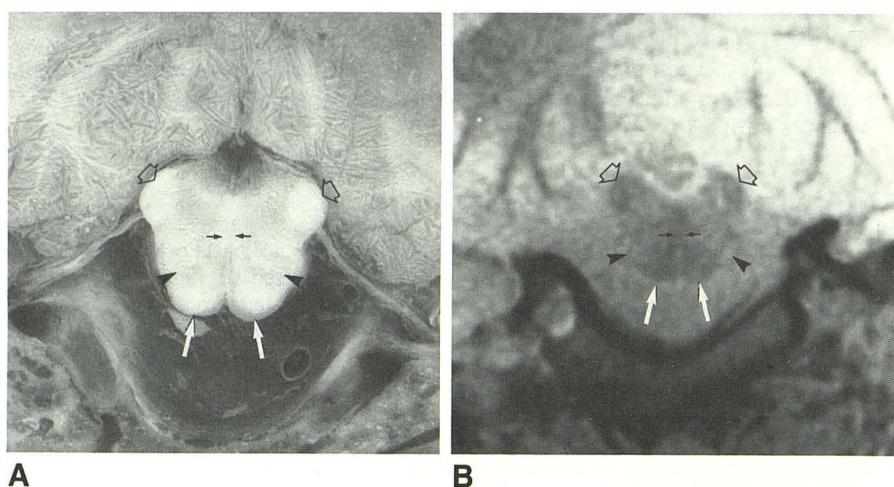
Anatomic and MR sections at level 1. Cryomicrotomic section (A), SE 800/20 MR image (B). The pyramidal tract (white arrows), medial lemniscus (small black arrows), inferior olivary nuclei (arrowheads), and restiform body (open arrows) are seen.
